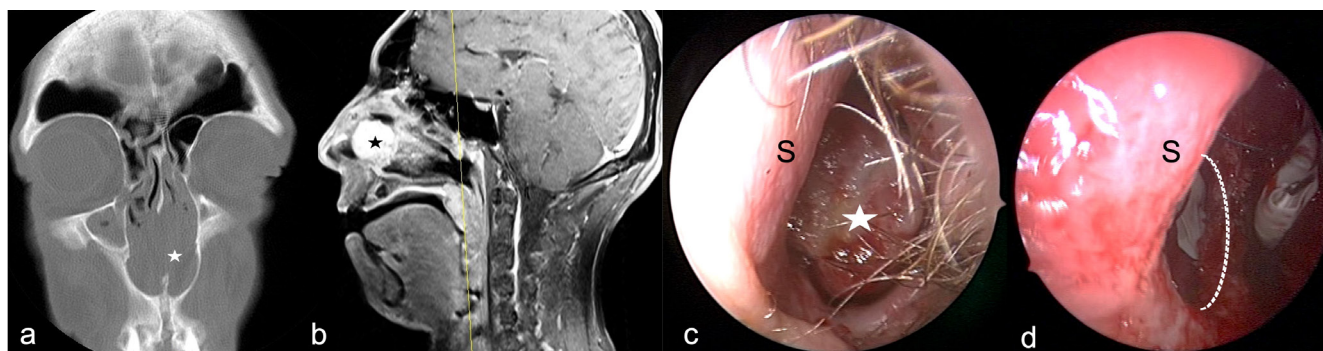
Preoperative a) coronal CT and b) sagittal MRI of the patient with nasal septum anterior originated lobullary capillary hemangioma (LCH) causing septal perforation c) endoscopic view of LCH d) Intraoperative view of septal perforation after complete resection S: nasal septum, * tumour.
